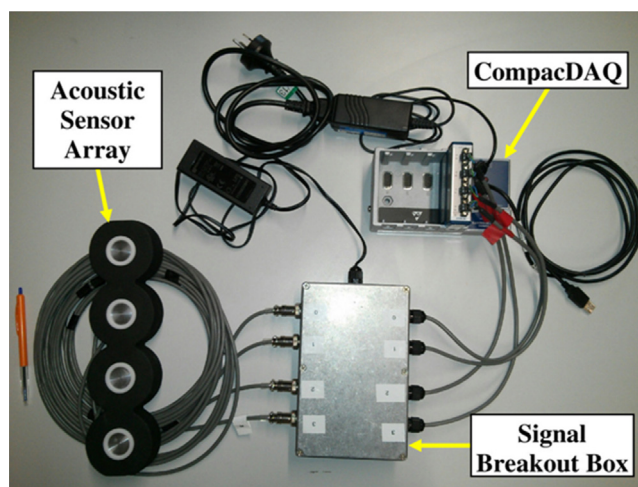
Image of data acquisition hardware which consists of four ultrasonic sensors arranged in an array, signal breakout box for external power input, and National Instruments CompacDAQ (A ball-point pen of length 140 mm has been included at the left of the image for scale).
